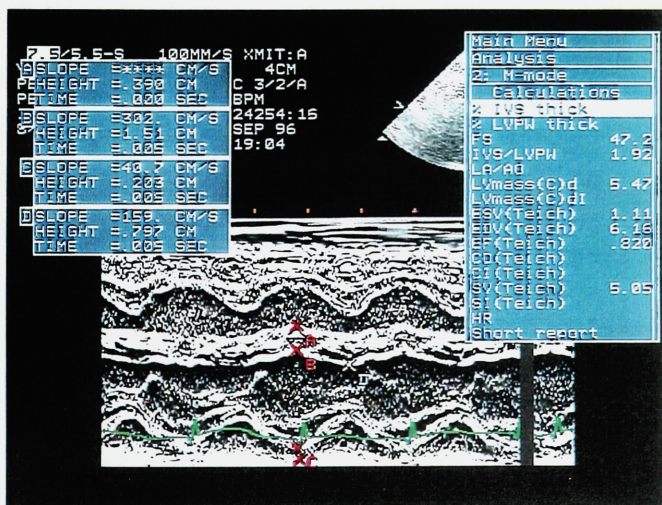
This is an M-mode echocardiogram a patient with HCM performed during the second week of life. The interventricular septum measures 0.390 cm and the posterior wall measures 0.203, with an abnormal IVS/LVPW of 1.92.
